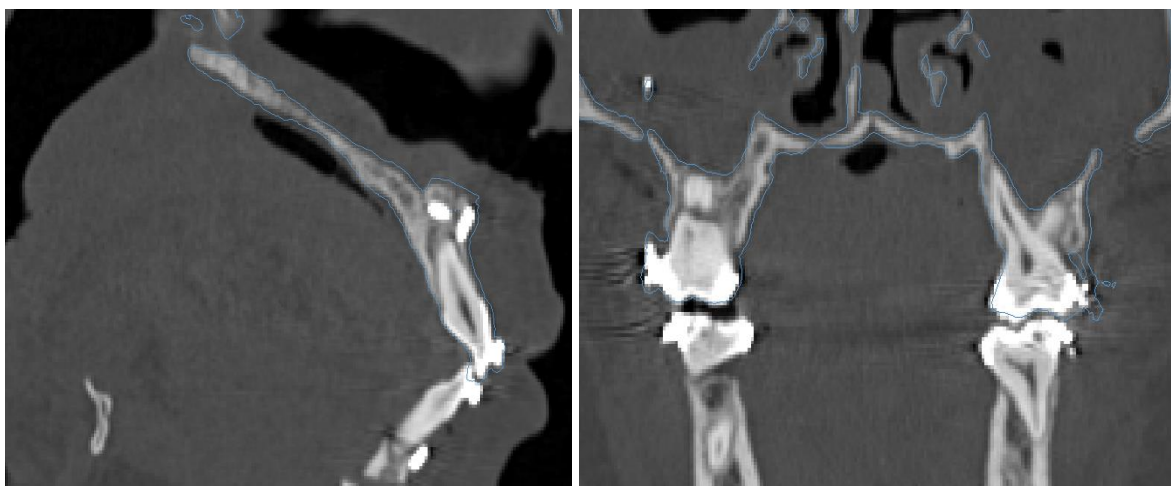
Immediate postoperative CT outline (Blue) overlapped Over the 4 months postoperative CT
